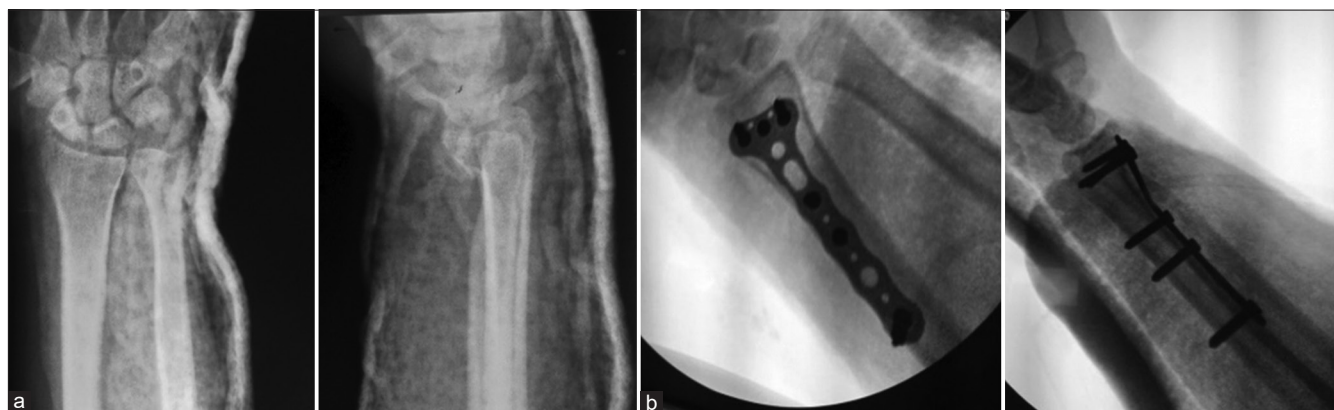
X-rays of the right wrist, PA view and lateral view. (a) Pre-operative and (b) post-operative
